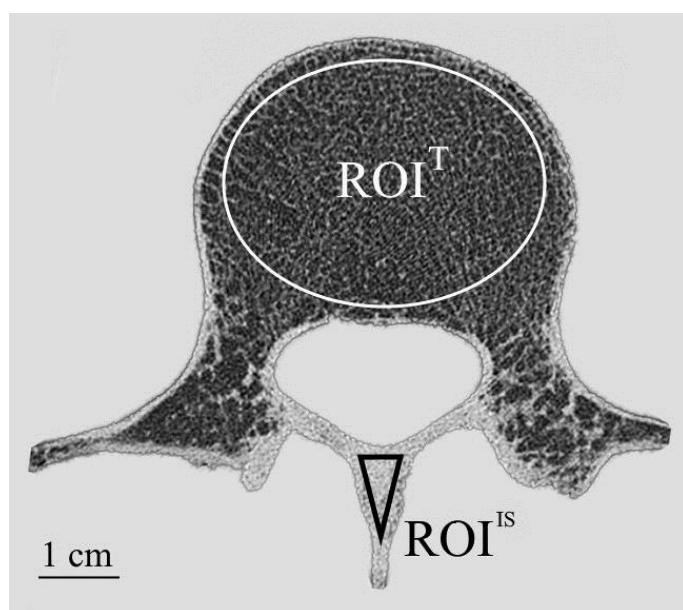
Representative 2D CT image of human vertebral cross sections. The regions of interest used for the calculation of the trabecular bone parameters (ROI^T) and for the normalization of the ROI^T histogram (ROI^{IS}) are marked.
